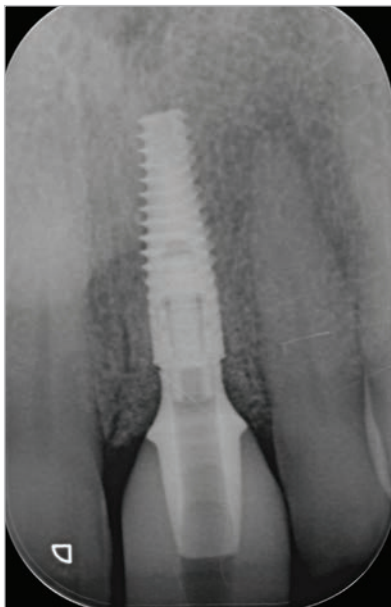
Radiographic control at final crown placement. Note the bone levels adjacent to the prosthetic abutment.
